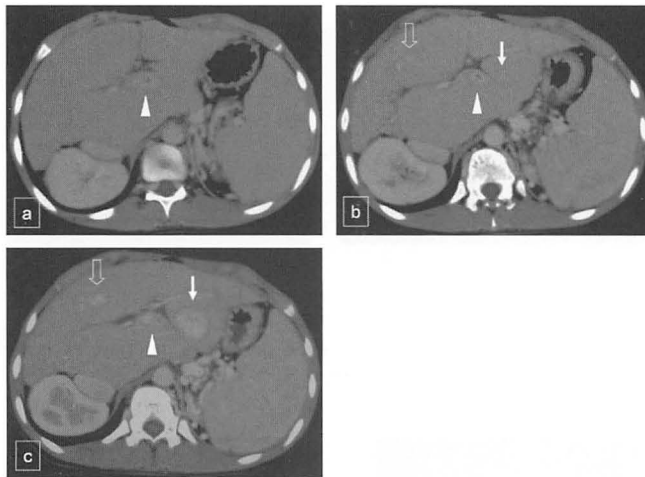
CT image (Portal phase)
